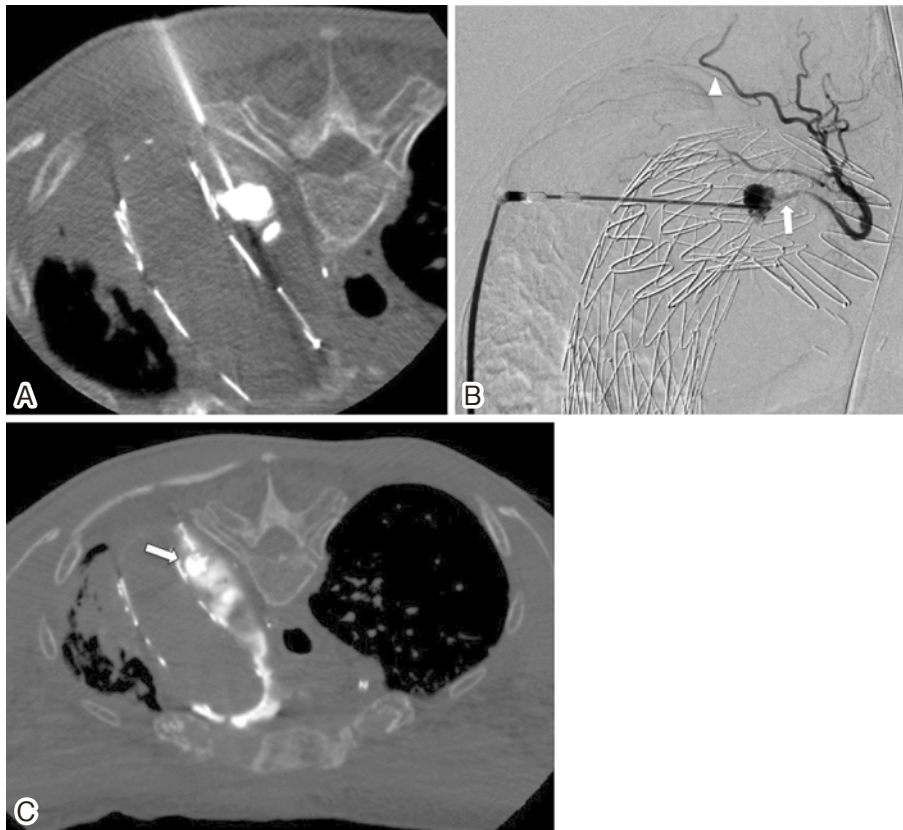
(A) Direct percutaneous puncture under CT guidance is performed using a coaxial technique. (B) Sacrography shows the endoleak nidus. The left second intercostal artery (arrow) and the left highest intercostal artery (arrowhead) are clearly visualized. (C) Postoperative non-contrast CT demonstrates that the NBCA cast has filled in the endoleak nidus (arrow).
